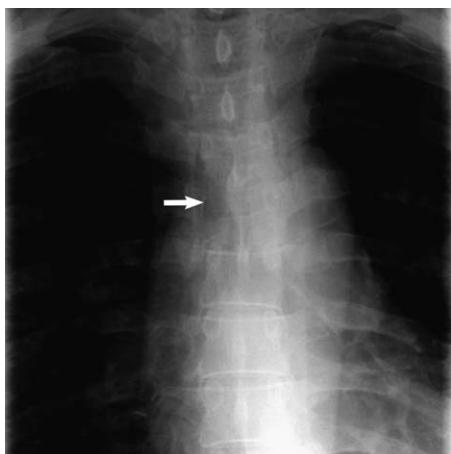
Anteroposterior plain radiograph shows a “missing” right T5 pedicle (*arrow*) correlating with biopsy-proven renal cell carcinoma metastasis.
